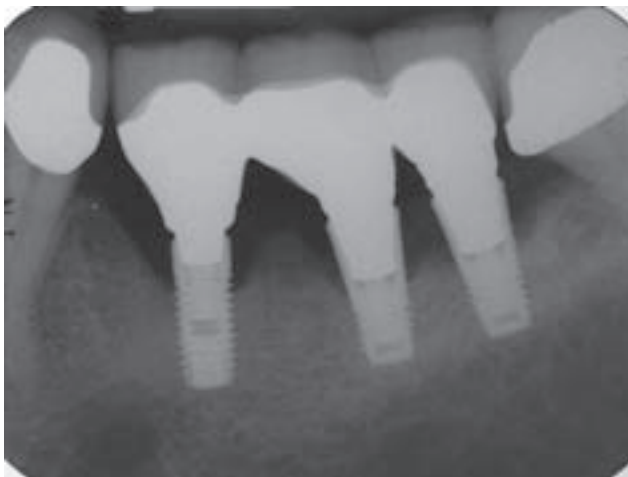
Radiograph of saucerized infrabony lesions associated with peri-implantitis.
